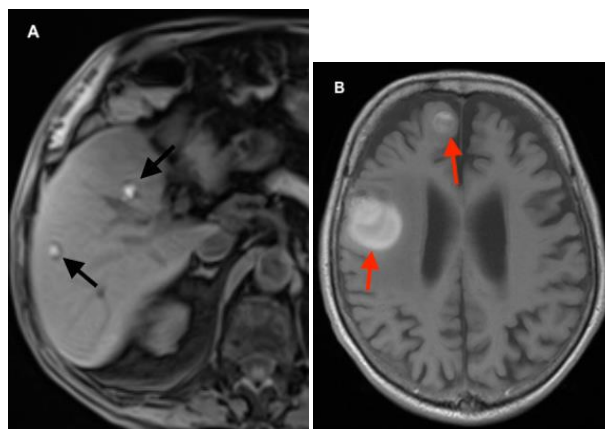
(A) Axial fat-suppressed T1-weighted MRI without contrast administration demonstrates two hyperintense liver lesions. (B) Axial T1-weighted MR image without contrast administration reveals two hyperintense lesions in the brain.
